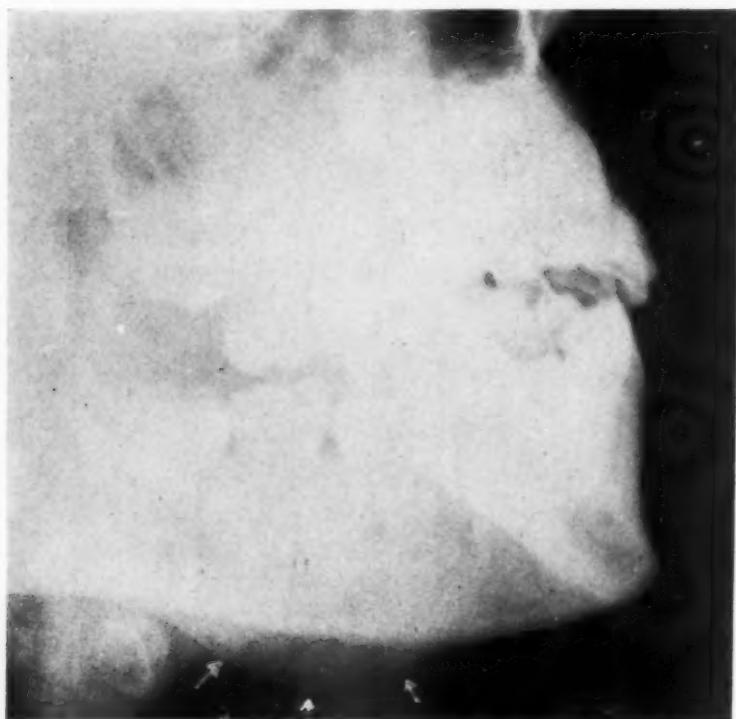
X-ray of right mandible, showing subperiosteal swelling.
